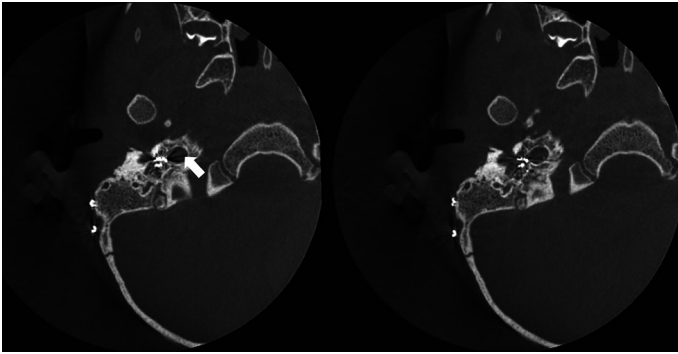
Axial CT showing electrodes directed into internal carotid canal (white arrow) instead of the cochlea.
